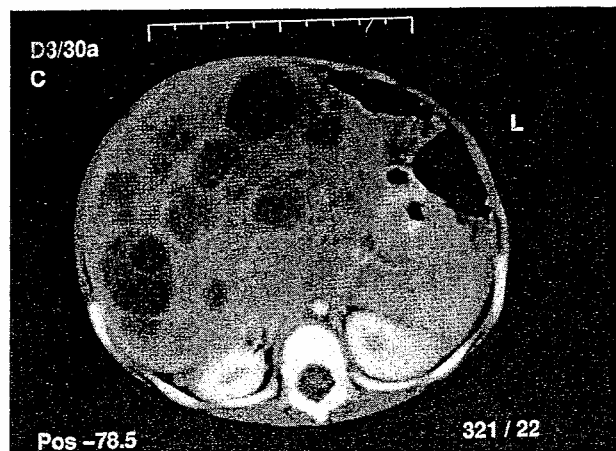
Abdominal CT showing a large, heterogeneous, solid and cystic hepatic mass that appears to be slightly compressing the right kidney.
